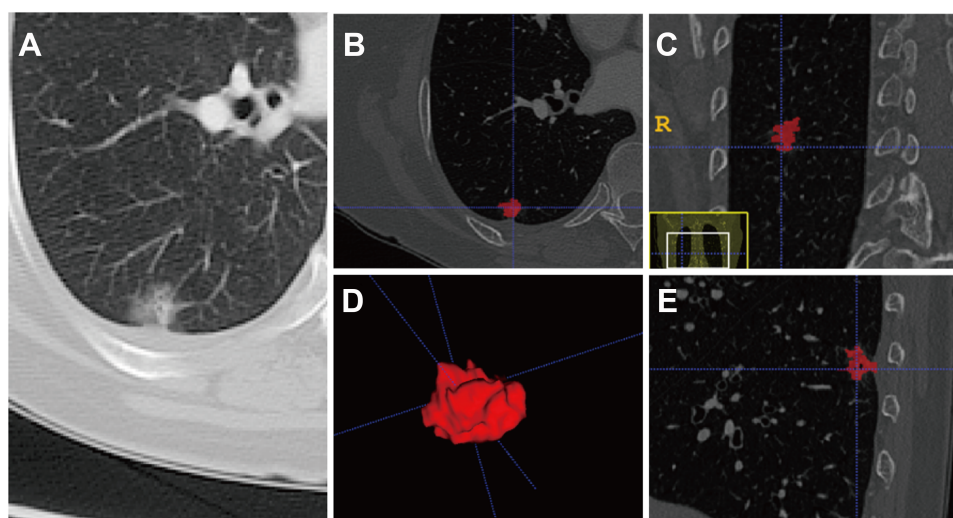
Images of a lung adenocarcinoma in right lower lobe without nodal involvement. (A) Axial thin-slice CT image. (B–E) Image segmentation and texture processing (B axial view, C coronal view, D volume rendering, E sagittal view). The TV, Avg, Mean, Skewness and Entropy values for this lesion were 1.8 cm³, -110 Hu, 84.53, 1.39 and 1.67, respectively.
